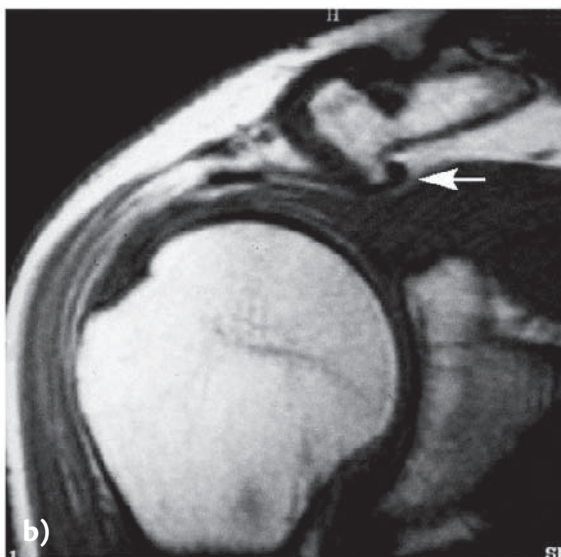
Impingement syndrome. a) Bony osteophytes under the clavicle after the Bigliani classification; b) MRI shows osteophytes as indicated by the arrow.
